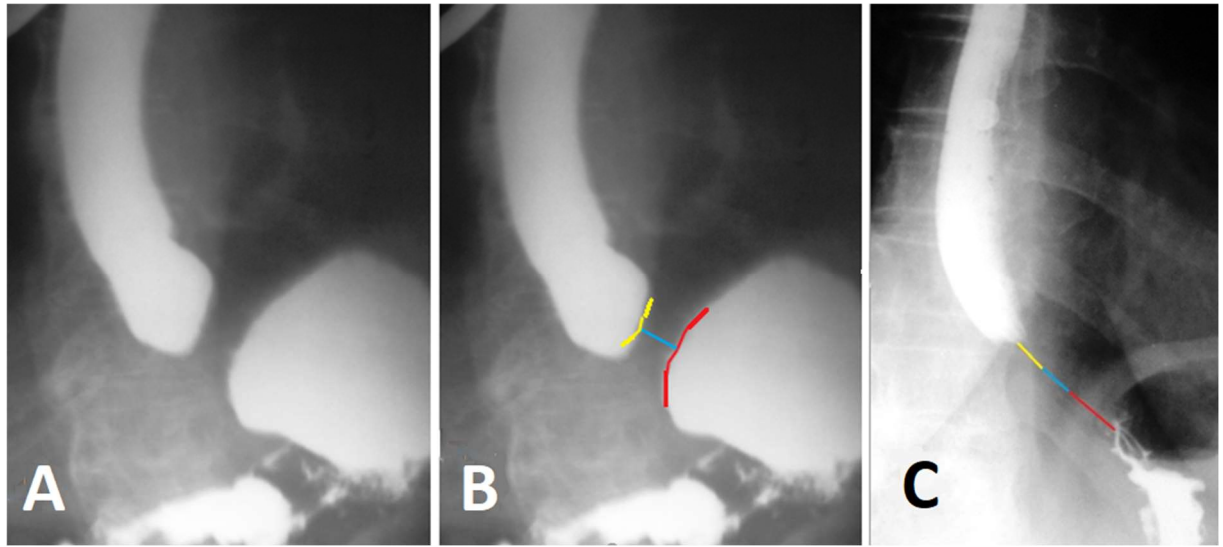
Radiographs of an adult patient with GERD. (A-B) - in a horizontal position with the abdominal compression. The sharp shortening of the LES as a result of the opening of the supra-diaphragmatic part of the LES (its walls are colored yellow) and the intraabdominal part of the LES (red color) is determined. Only the intra-diaphragmatic part of the sphincter is in the contracted state. (C) - in the vertical position all three components of the LES are in the contracted state.
